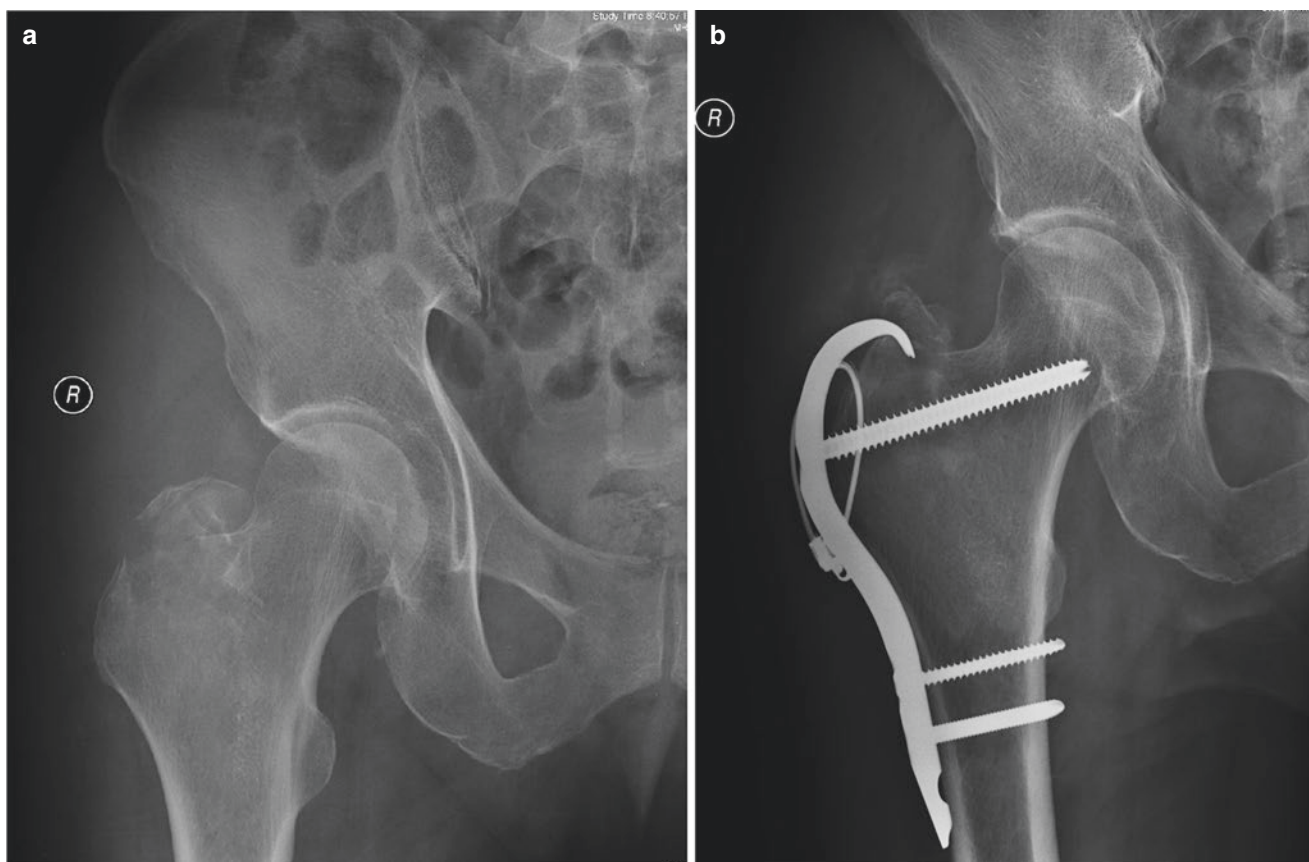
(a) AP radiograph showing a displaced greater trochanter fractures. (b) Treatment with a hook plate and cerclage wires
